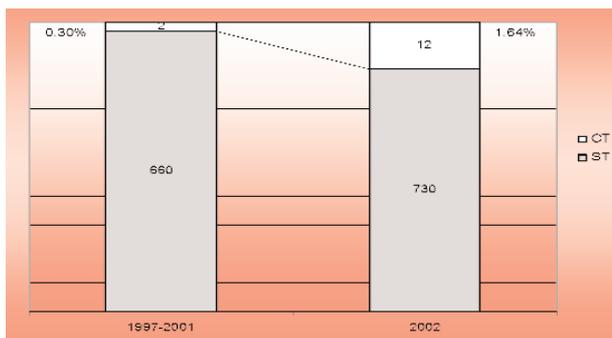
Six-fold increase from the number of documented occurrences of CT during the period between 1997 and 2001 (average of 0.30% from the 650 documented occurrences with ST)
